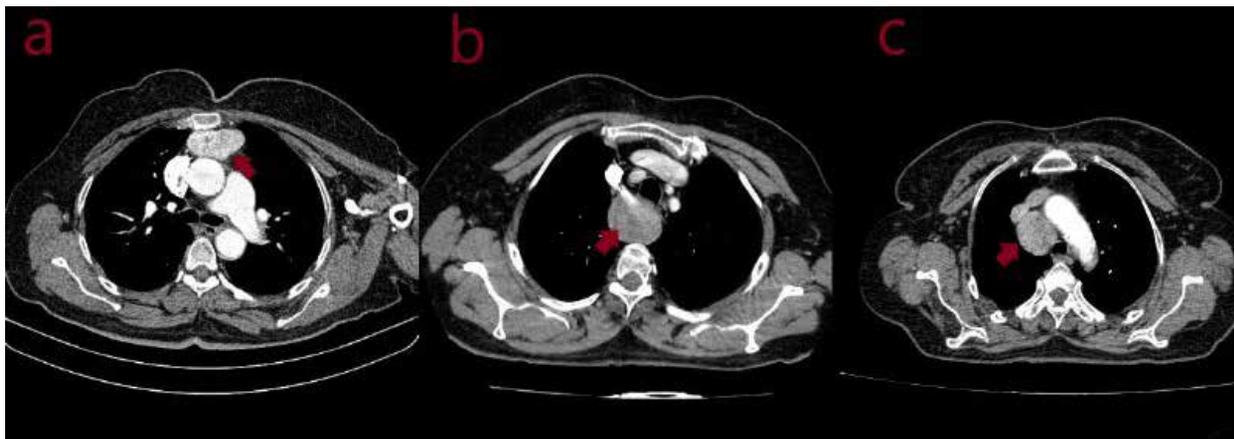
A. Chest CT image of the patient with large paratracheal ETT. Because of the size of the mass, we preferred right thoracotomy. B. Anterior mediastinal ETT was seen in this chest CT. ETT was excised with the incision of partial sternotomy.
